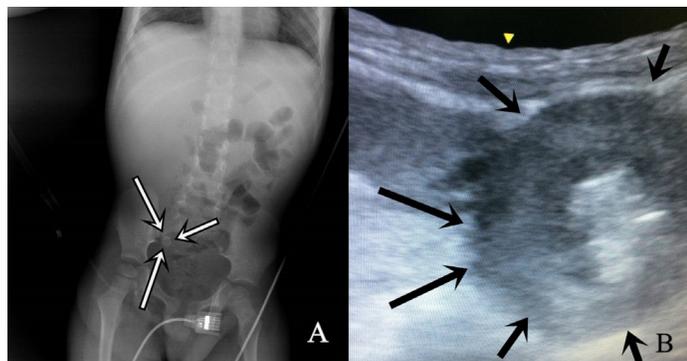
A. This image shows a plain abdominal x-ray of an acute appendicitis patient of a 6-year-old male. The arrows indicate fecality which causes appendicitis
